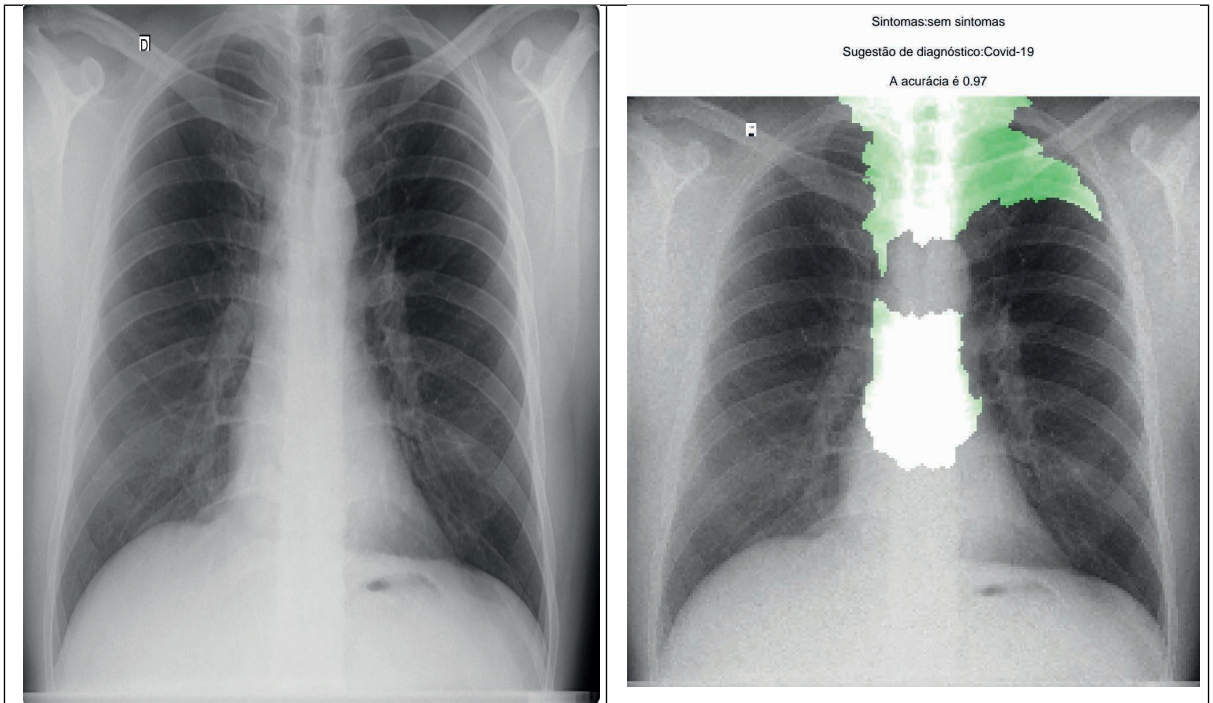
(A) Image of the Chest X-Ray; (B) Identification of Covid-19 changes in the upper respiratory system.
